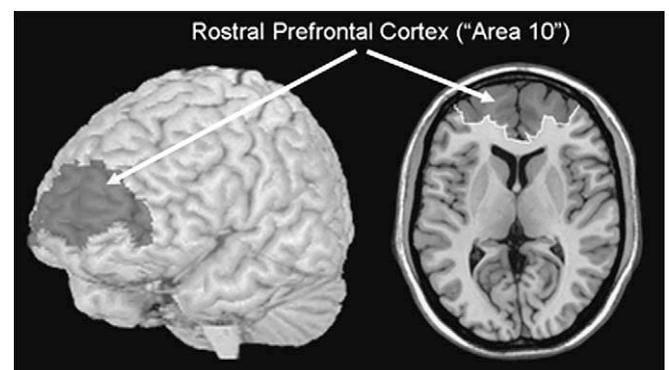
Approximate location of rostral prefrontal cortex, or Brodmann Area 10, of the human brain, shown in dark gray. The left panel shows the lateral surface and the right panel shows an axial slice of a T1-weighted anatomical MRI image.
